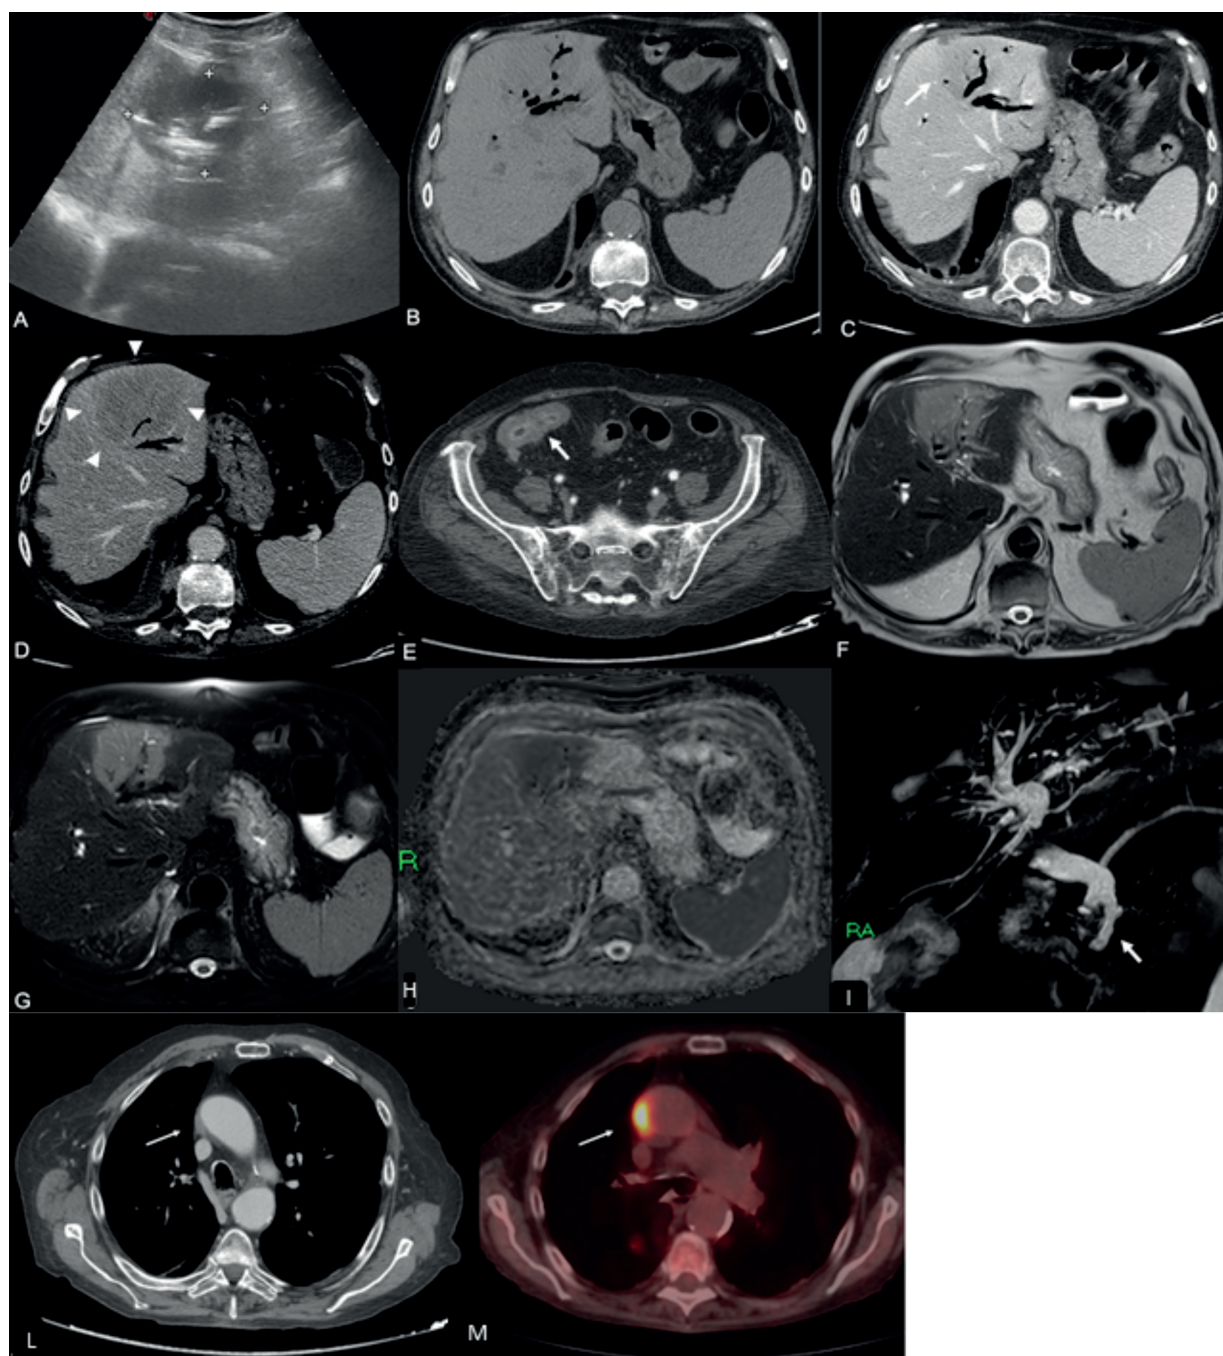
(Panels a-m). Panel a. Ultrasound scan showing in the II, IV, V hepatic segments the presence of a inhomogeneous hypoechoic lesion containing an alternation of anechoic, hypoechoic and hyperechoic mobile artifacts as for the presence of gaseous material (pneumobilia). Panel b. Axial CT examination: unenhanced scan demonstrates pneumobilia with isodense hepatic lesion in the IV, III and II segments. Panels c, d. Venous (c) and delayed phase (d) Computed Tomography (CT)-scan demonstrates slight hypodensity in the hepatic lesion with regular path of the intrahepatic vessels without signs of stricture-infiltration (arrow and arrowheads). Panel e. CT images also visualize an increased bowel thickness of the pre-anastomotic ileum related to post-operative recurrence of CD (arrow). Panels f-h. Magnetic Resonance (MR) axial imaging in T2-weighted sequences without (f) and with fat-suppression (g), confirmed the intrahepatic lesion with hyperintense signal. Diffusion weighted imaging with ADC demonstrated restriction of signal (h). Panel i. MR-Cholangiopancreatography: coronal image demonstrates choledocholithiasis in pre-papillary region (arrow). Panel l. Contrast enhanced chest CT-scan (panel a) in January 2019, visualizing a small, not enlarged para-aortic lymph node (arrow). Panel m. CT/PET with FDG performed in May 2019, detecting an enlargement of the para-aortic lymph node, showing an increased size when compared to previous CT imaging, associated with pathological uptake of radiotracer (arrow).
